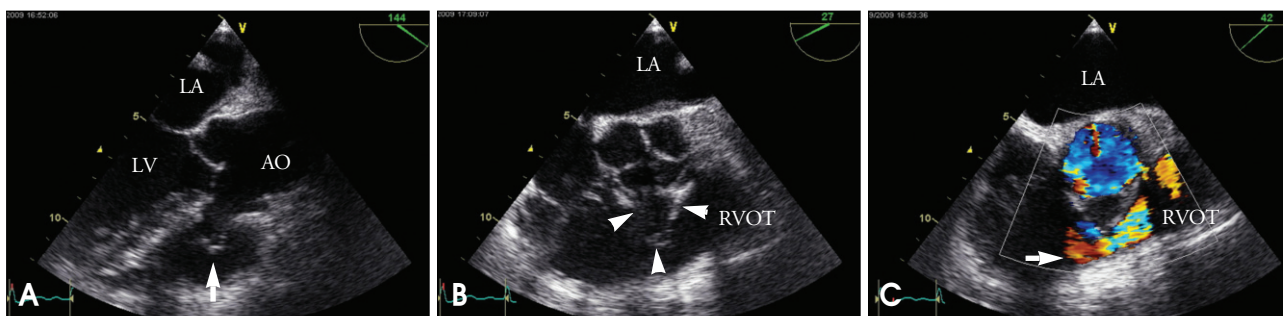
Transesophageal echocardiography. Midesophageal aortic valve long-axis view at 144° C rotation demonstrating the SVA originating from the right coronary sinus of Valsalva (arrow) (A). Short-axis view at 27° C rotation demonstrating the SVA protruding into the RVOT (arrowheads) (B). Color Doppler shows flow acceleration due to the RVOT obstruction without shunt flow suggesting SVA rupture (arrow) (C). SVA: sinus of Valsalva aneurysm, RVOT: right ventricular outflow tract, LV: left ventricle, LA: left atrium, Ao: aorta.
